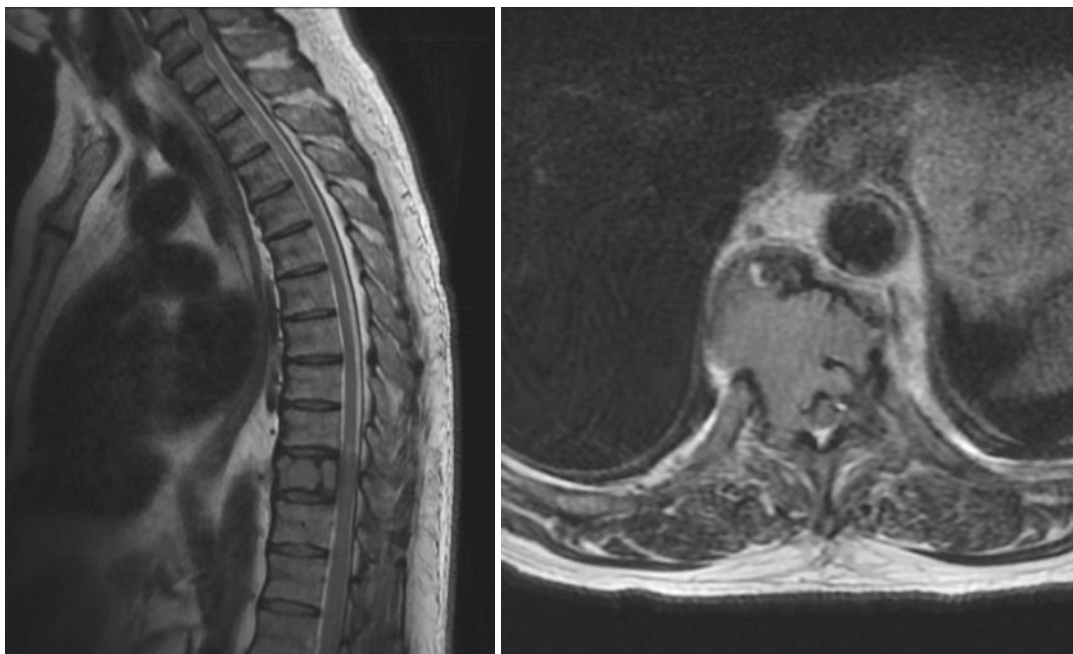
MRI demonstrating T10 pathologic fracture with retropulsion and mild canal stenosis. Multiple myeloma often has normal bone marrow signal with diffuse involvement
